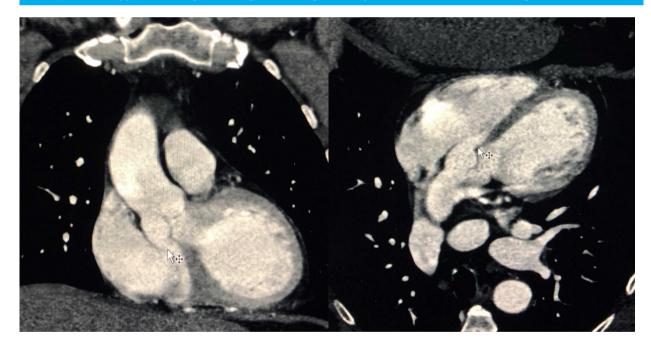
CT aortogram showing the ruptured sinus of valsalva with communication into right atrium (white arrow).
